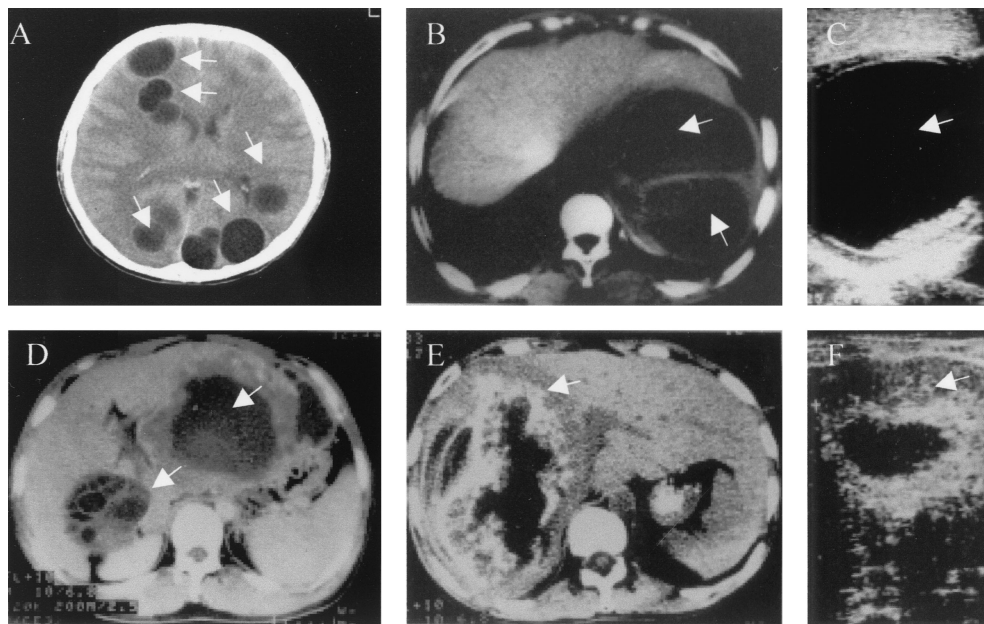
Clinical images of CE and AE. (A) CT scan of a brain with CE. (B) CT scan of a liver with CE. (C) Sonogram of a liver with CE. (D) CT scan of a liver with both AE and CE (note the presence of daughter cysts). (E) CT scan of a liver with AE. (F) Sonogram image of a liver with AE. Cysts (CE) or cyst masses (AE) are arrowed.
